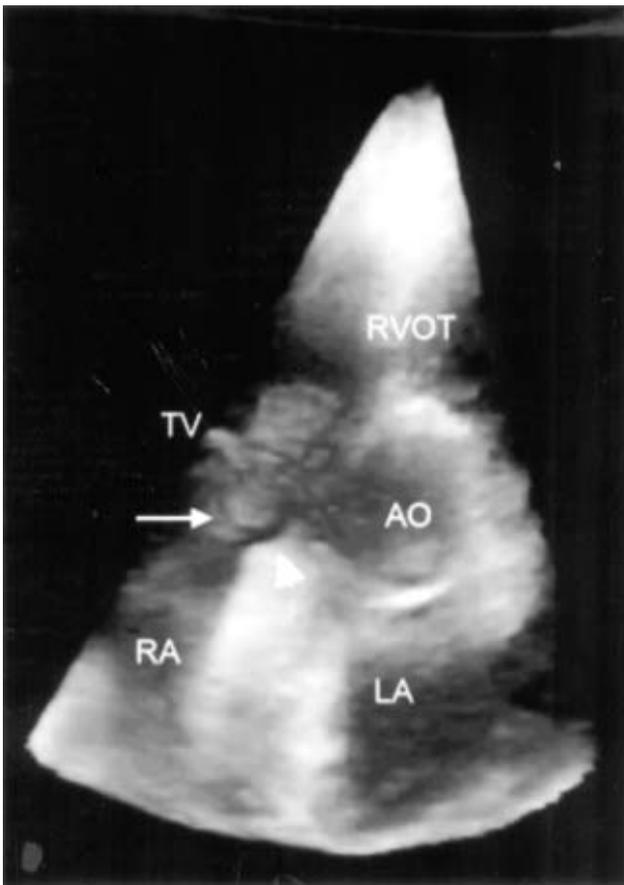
Real-time three-dimensional echocardiography with short-axis projection showing an aortocardiac fistula (arrow head) beneath the noncoronary cuspid with vegetation (arrow) in the right atrium (RA). The tricuspid valve (TV) is spared from infection. AO, aortic ring; LA, left atrium; RVOT, right ventricular outflow tract.
